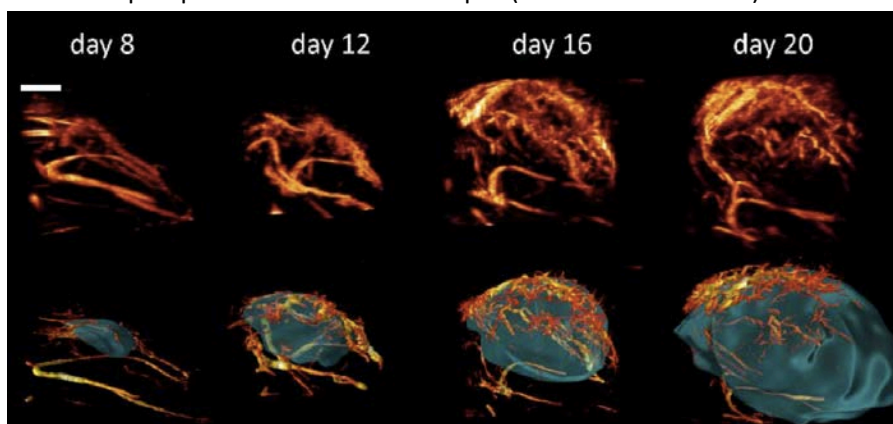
Ultrafast Doppler tomography (UFD-T) used for monitoring tumor angiogenesis. Top row: Maximum Intensity Projection (MIP) rendering of the 3D vascular volume acquired via UFD-T. Bottom row: volume rendering of the segmented tumor and of the skeletonization of the UFD-T volume. Scale bar 2 mm. Figure from (Demene et al. 2014).
